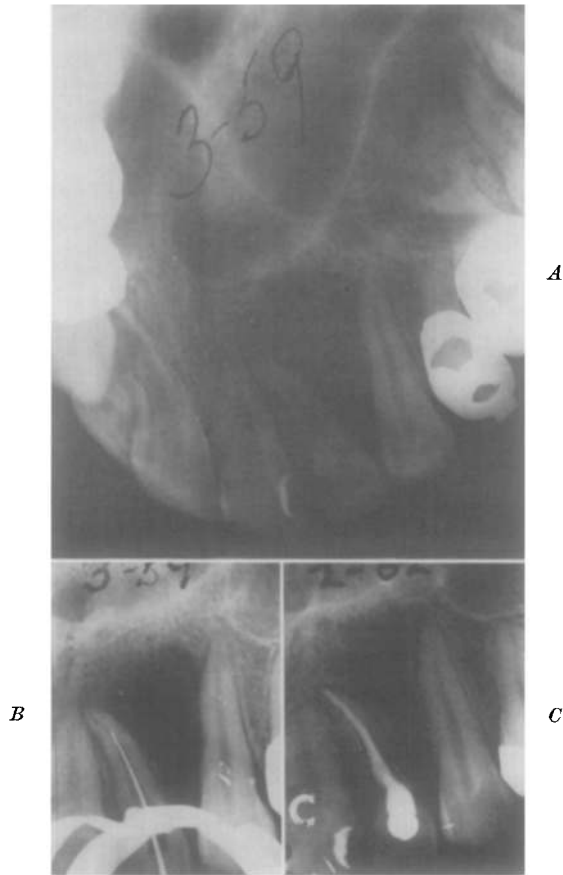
A, Occlusal roentgenogram showing extent of lesion and root displacement of lateral incisor and cuspid teeth. B, Intraoral film of lesion. C, Thirty-five months following treatment showing resolution and repositioning of lateral incisor and cuspid roots.
